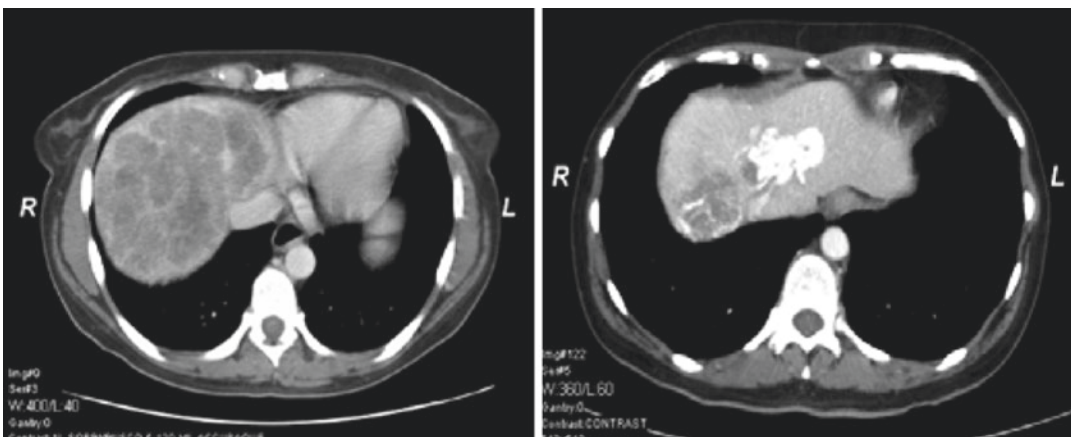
CT-scan of a 38-year-old female patient with synchronous hepatic metastases from a rectosigmoid carcinoma before (*left*) and after (*right*) FOLFIRI/cetuximab chemotherapy showing a partial radiologic response
